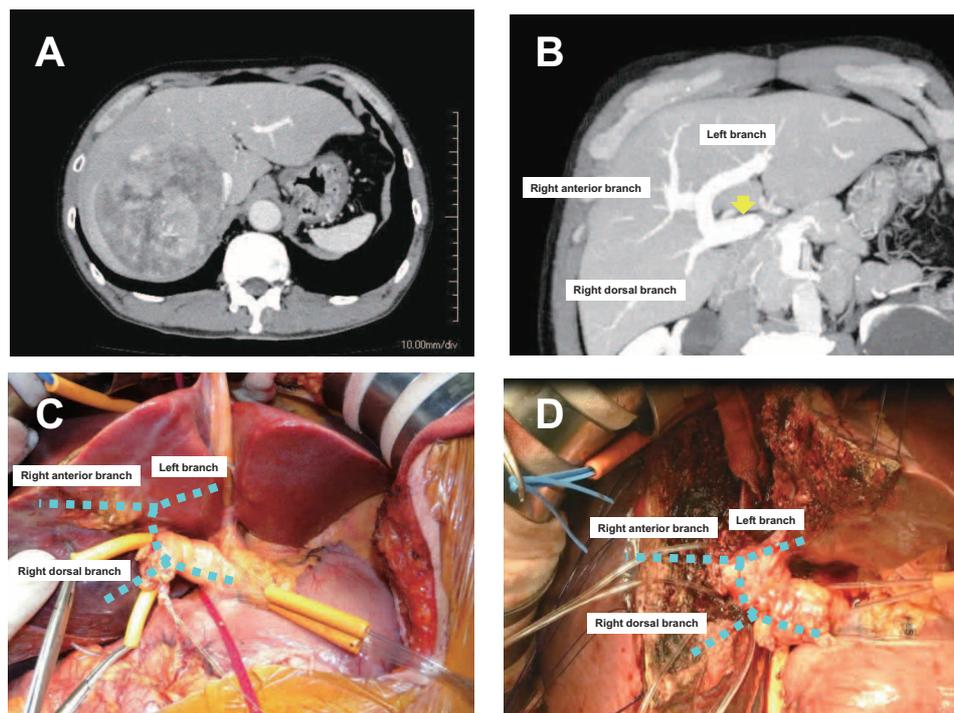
(A) Preoperative computed tomography imaging of the 10-cm tumor in the right hepatic lobe. (B) Maximum intensity projection imaging of the absence of portal vein bifurcation (yellow arrow) with an aberrant left branch originating from the right anterior branch. Intraoperative picture (C) prior to hepatic resection and (D) during hepatic resection showing the structure of the portal system (blue dotted lines).
